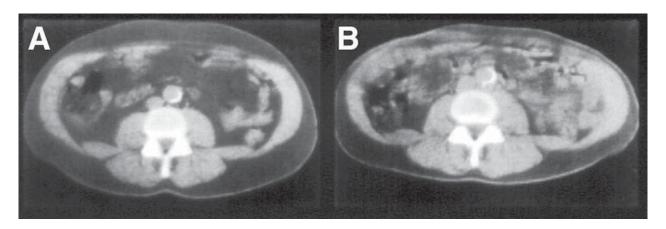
Computed tomography scan at the L3/L4 level before (a) and after (b) 26 weeks of GH therapy. Both subcutaneous and visceral adipose tissue decrease with therapy. Reprinted with permission from Bengssson, B. A. et al. (1993). *J. Clin. Endocrinol. Metab.* 76, 315.
